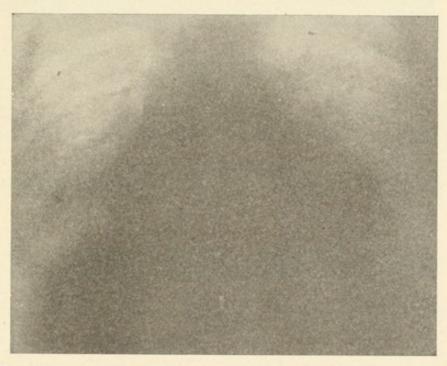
Angina pectoris. During the attack. (X-ray photograph of the heart.)
